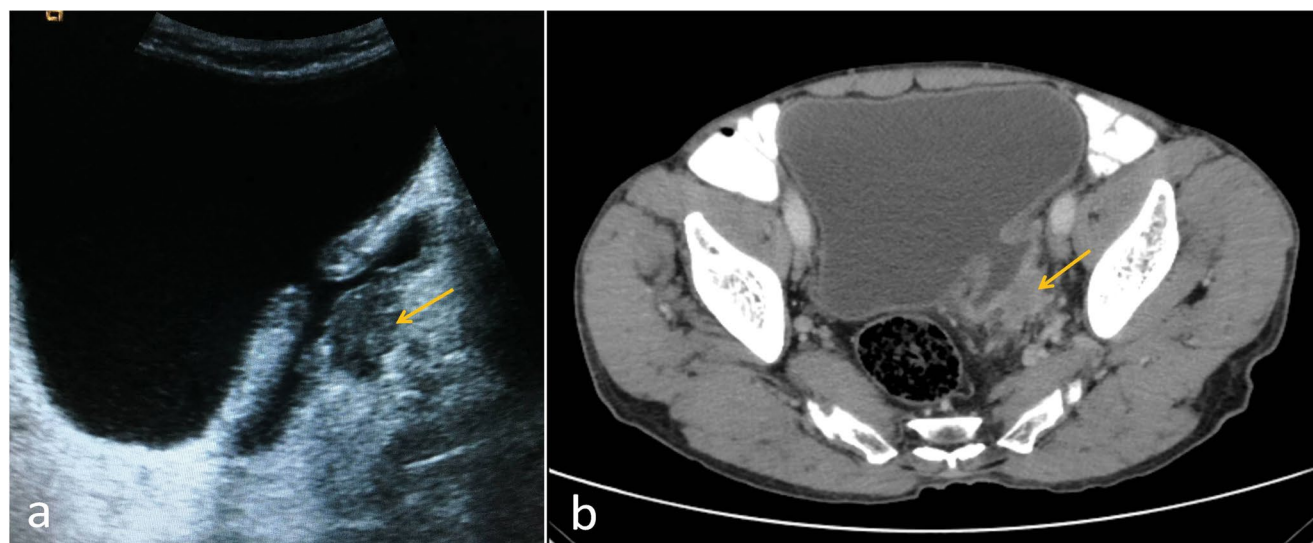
Contrast-enhanced abdominal computed tomography demonstrates a bladder diverticulum protruding from the left posterior lateral wall with irregular wall thickening in the diverticulum.
